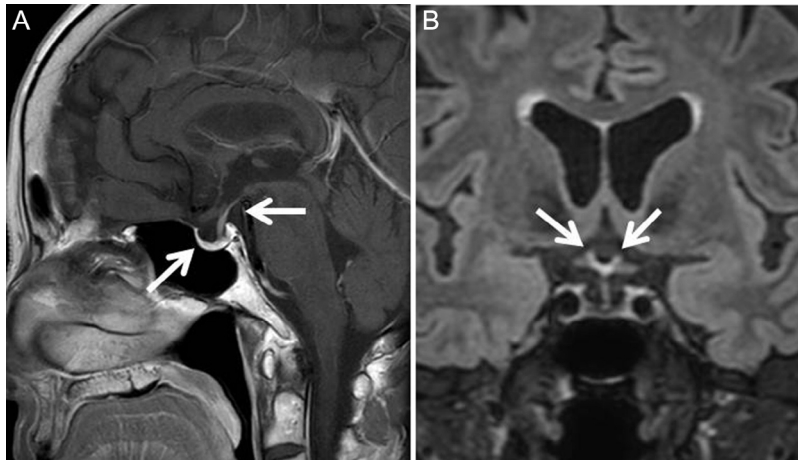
(A) Follow-up sagittal postcontrast T1-weighted image showing a decrease in the pituitary lesion after steroid therapy (arrows). (B) High-signal intensity in the tuber cinereum not completely eliminated on coronal 3D FLAIR imaging (arrows).
